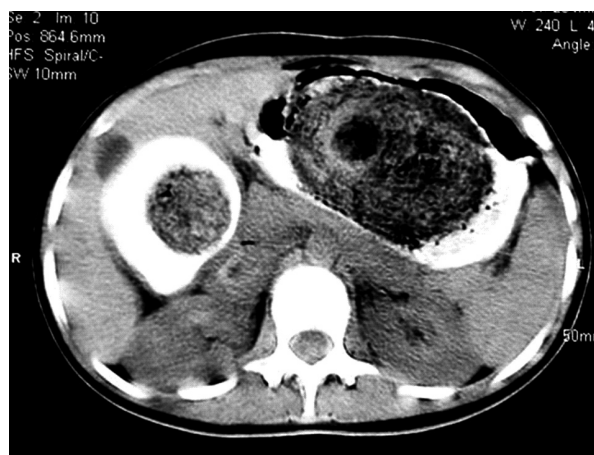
Computed tomography image of a trichobezoar in the stomach
